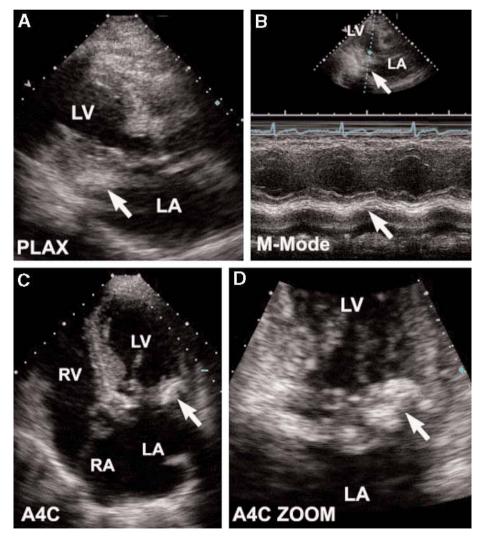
An 86-yr-old woman with generalized sepsis. Parasternal long-axis still frame (suboptimal quality) show an echodense lesion near the posterior mitral valve annulus, the most common site for mitral annular calcification. On transesophageal echocardiography, a circumferential opacity with a central echolucent region was seen (*see* Fig. 5).
